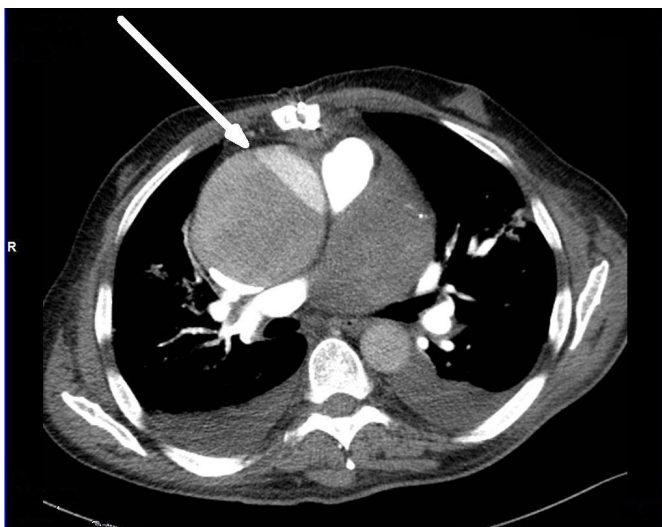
Preoperative 64 multislice computed tomography of the chest. Arrow points acute aortic dissection (Stanford A).
